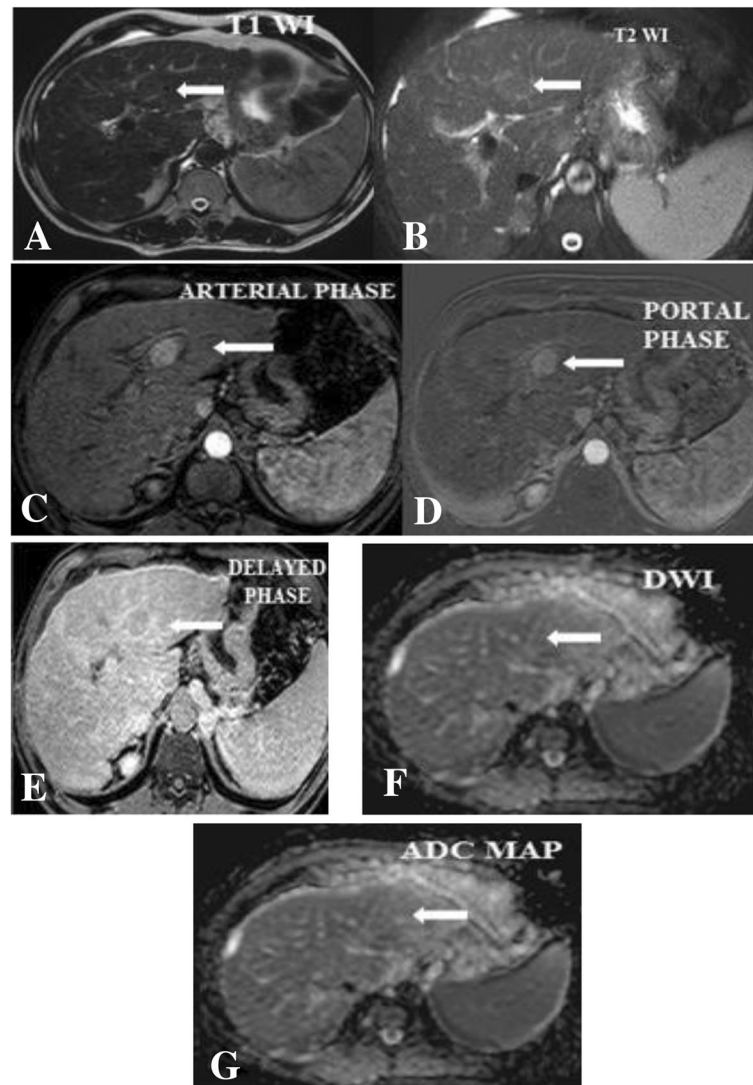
A 60-year-old male patient post-transarterial chemoembolization. a An axial unenhanced T1W image showed newly appeared in the right lobe segment IVA focal lesion of isointense signal (arrow). b An axial T2W image showed a lesion of slight high signal (arrow). c An axial post-contrast arterial phase shows homogenous contrast enhancement (arrow). d, e An axial portal and the delayed gadolinium-enhanced image showed gradual contrast washout (arrow). f, g DWI shows the lesion to be restricted, and ADC MAP showed the lesion of low signal intensity with ADC value of $0.9 \times 10^{-3} \text{ mm}^2/\text{s}$. Suggested MR diagnosis: hepatocellular carcinoma. Biopsy results: hepatocellular carcinoma
